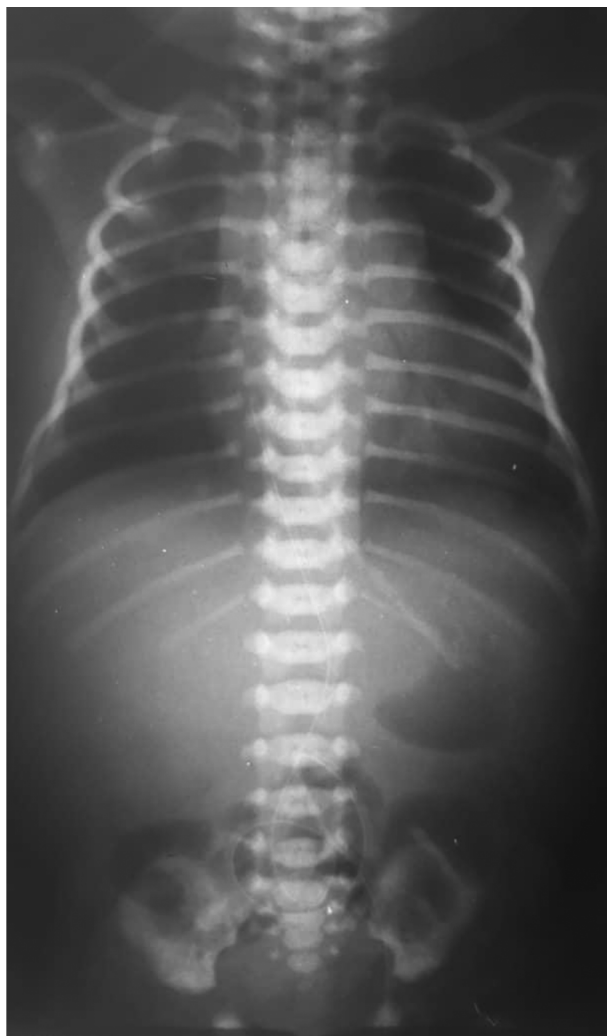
The second chest X-ray of neonate at first birth of day after injection of second dose of surfactant: mild hyperinflation that was decreased in comparison to previous CXR
